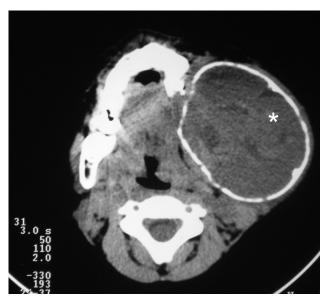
Axial CT image showing an ABC at the left angle of the mandible (asterisk).
